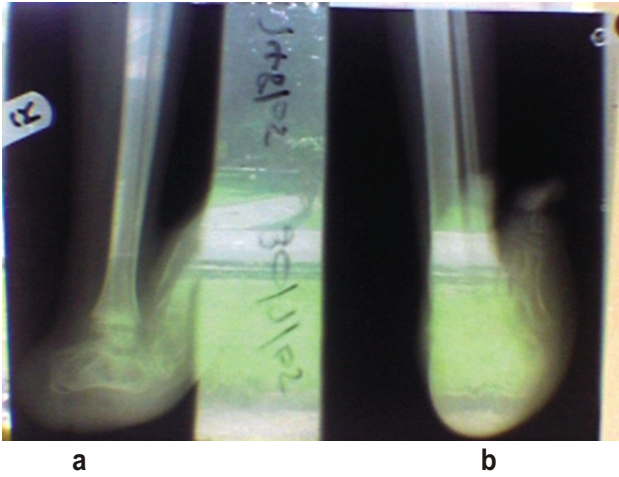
Plain radiographs of the right leg and foot of the patient.
